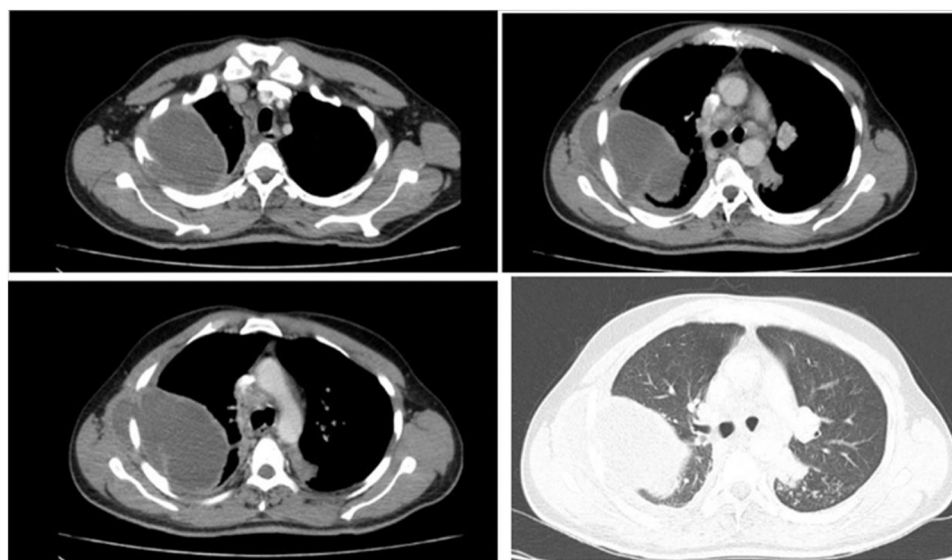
A CT scan chest showed micronodular infiltrates with tree in bud appearance with adjacent consolidation in the superior segment of the left lower lobe. Loculated right apical pleural collection with pleural enhancement is seen measuring 9 × 7.5 cm, dissecting the adjacent lateral chest wall and eroding the posterior arch of the 3rd right rib.
